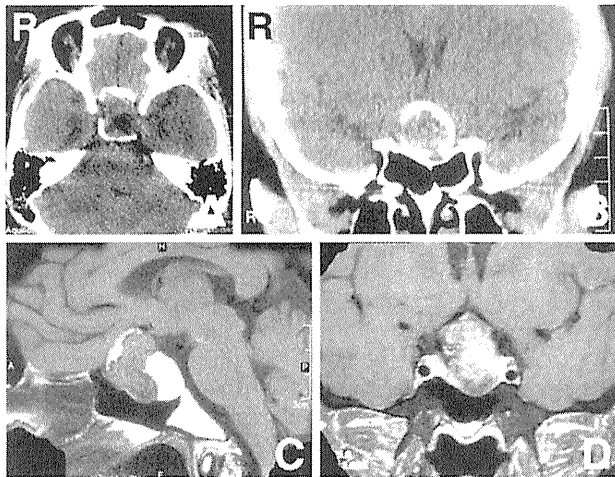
A, B: Preoperative axial (A) and coronal (B) computed tomography scans showing mass lesions with extremely thick calcification, here called “armor-like calcification,” extending from within the sella turcica to the suprasellar region. C: Preoperative sagittal T₁-weighted magnetic resonance image showing well-demarcated anterior solid and posterior cystic components. D: Preoperative coronal T₁-weighted magnetic resonance image with gadolinium showing heterogeneous enhancement of the solid components.
